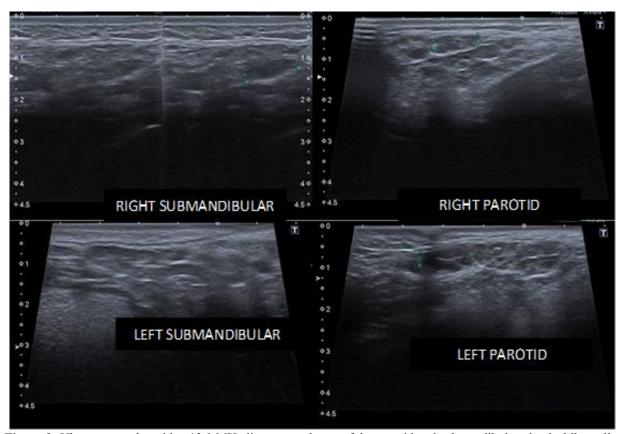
Ultrasonography with a 12.0 MHz linear transducer, of the parotid and submandibular glands, bilaterally.
